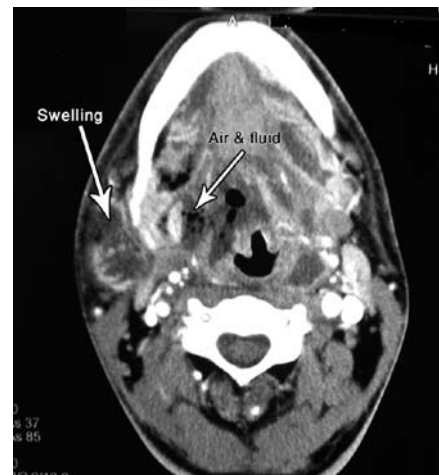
Axial neck CT post-contrast shows right parapharyngeal heterogeneous soft tissue swelling with air and fluid collection at its center (abscess) extending laterally beside the right mandibular ramus. The lesion is associated with marked soft tissue edema extending to the epiglottic area.
